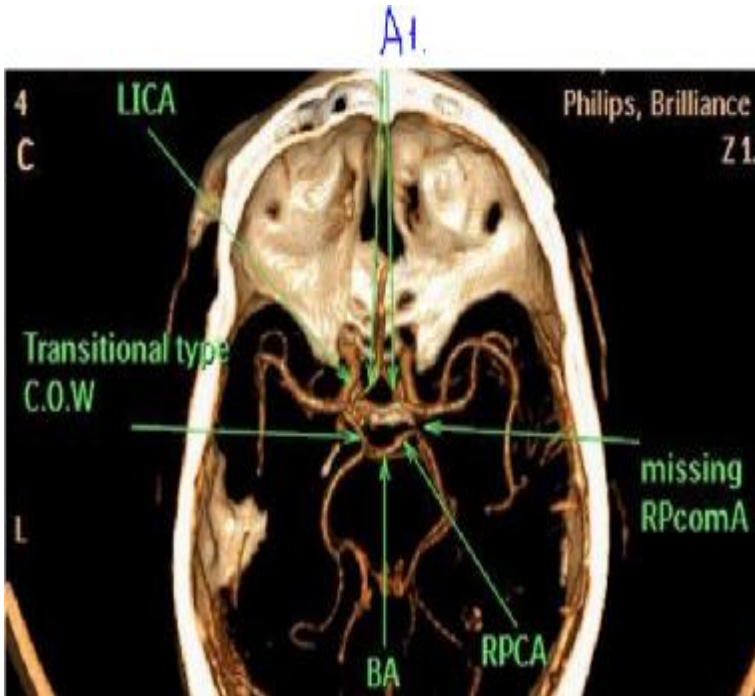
CTA shows Lt. transitional fetal type posterior circle of Willis and missing RPcomA.
